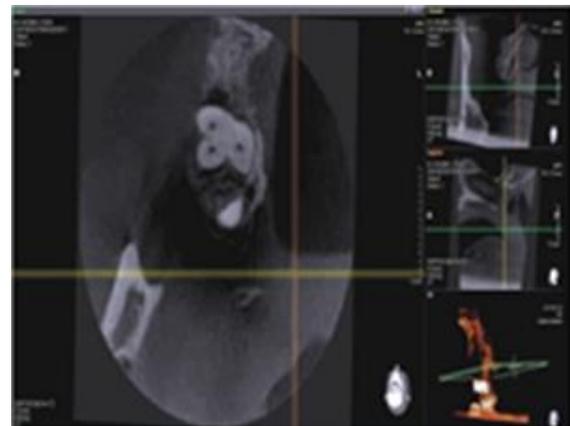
Axial CBCT images for maxillary right second molar confirmed the presence of an additional canal.
